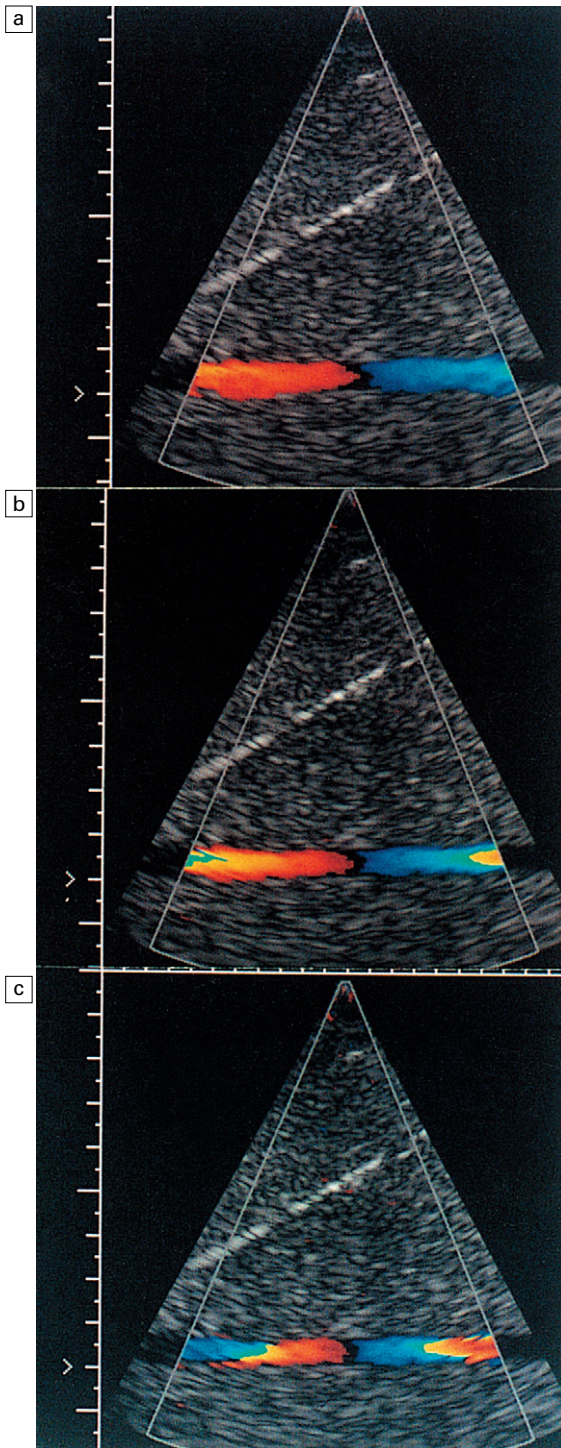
Aliasing in a colour Doppler velocity image. Note that there is no black space between the red and blue pixels in the lateral colour displays, indicating that the pixel colour-coding has gone off the top of the red colours and wrapped round to the blue colours. However, there is a black space between the colour displays centrally, indicating reversal of flow direction in relation to the transducer.
